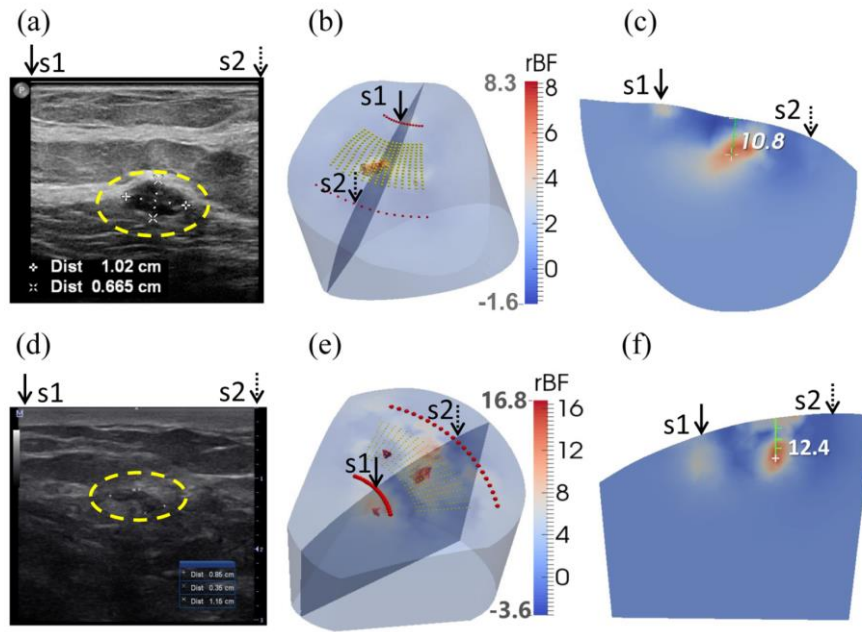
Clinical examples of two low-grade carcinomas in situ. (a) Ultrasound image of breast with a tumor (inside the yellow dashed circle) in the first patient. The tumor mass center is located at 19.2 mm beneath the skin surface. (d) Ultrasound image of breast with a tumor (inside the yellow dashed circle) in the second patient. The tumor mass center is located at 13.3 mm beneath the skin surface. (b) and (e) show the reconstructed 3-D tumor blood flow contrasts imaged by the ncDCT in the first and second patients, respectively. For the comparison of ultrasound and ncDCT results, an ultrasound imaging plane along the transducer line and across the overlapped two specific light sources (S1 and S2) of ncDCT (see Fig. 4) is presented in the 3-D reconstructed image. The backgrounds are presented with 30% transparency of the original color clarity. (c) and (f) show the cross-section views through the reconstructed tumor centers, which can be directly compared to the 2-D ultrasound tumor images [(a) and (d)], respectively. This figure is reproduced from Fig. 8 in the reference (He *et al.*, 2015).
